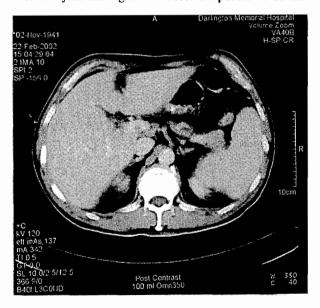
CT scan of abdomen showing the partial occlusion of the portal vein by thrombus.
